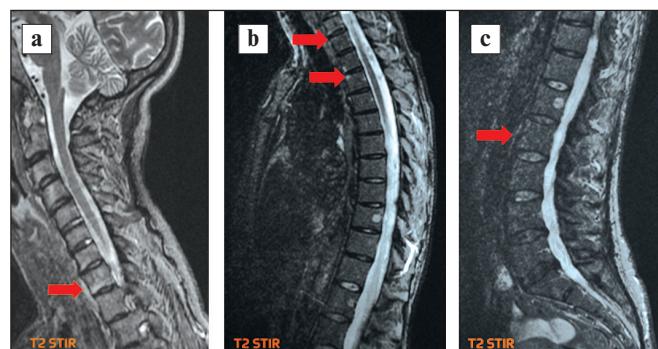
MRI of the cervical (a), thoracic (b), and lumbar (c) spine using STIR. Arrows show lesions: bone marrow edema – active spondylitis in all three spinal regions
